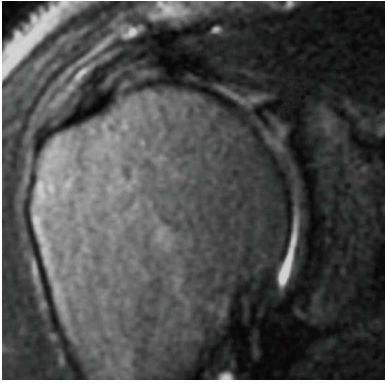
Magnetic resonance image of a Type 2 SLAP tear with concomitant partial thickness rotator cuff tear.
